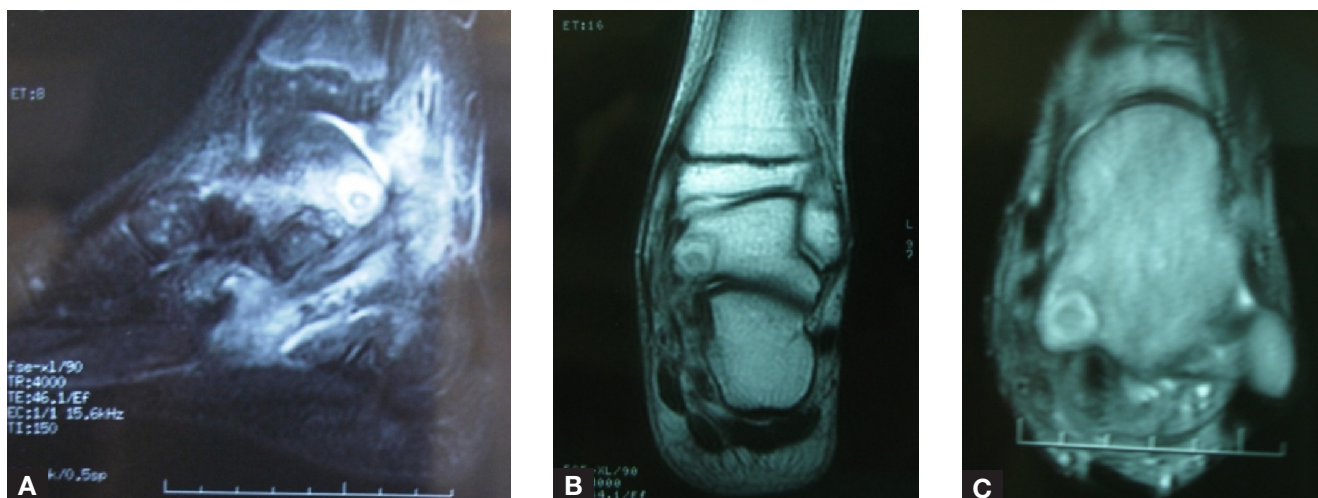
Sagittal (A), coronal (B), and axial (C) magnetic resonance imaging shows lesion in posteromedial aspect of talus.
